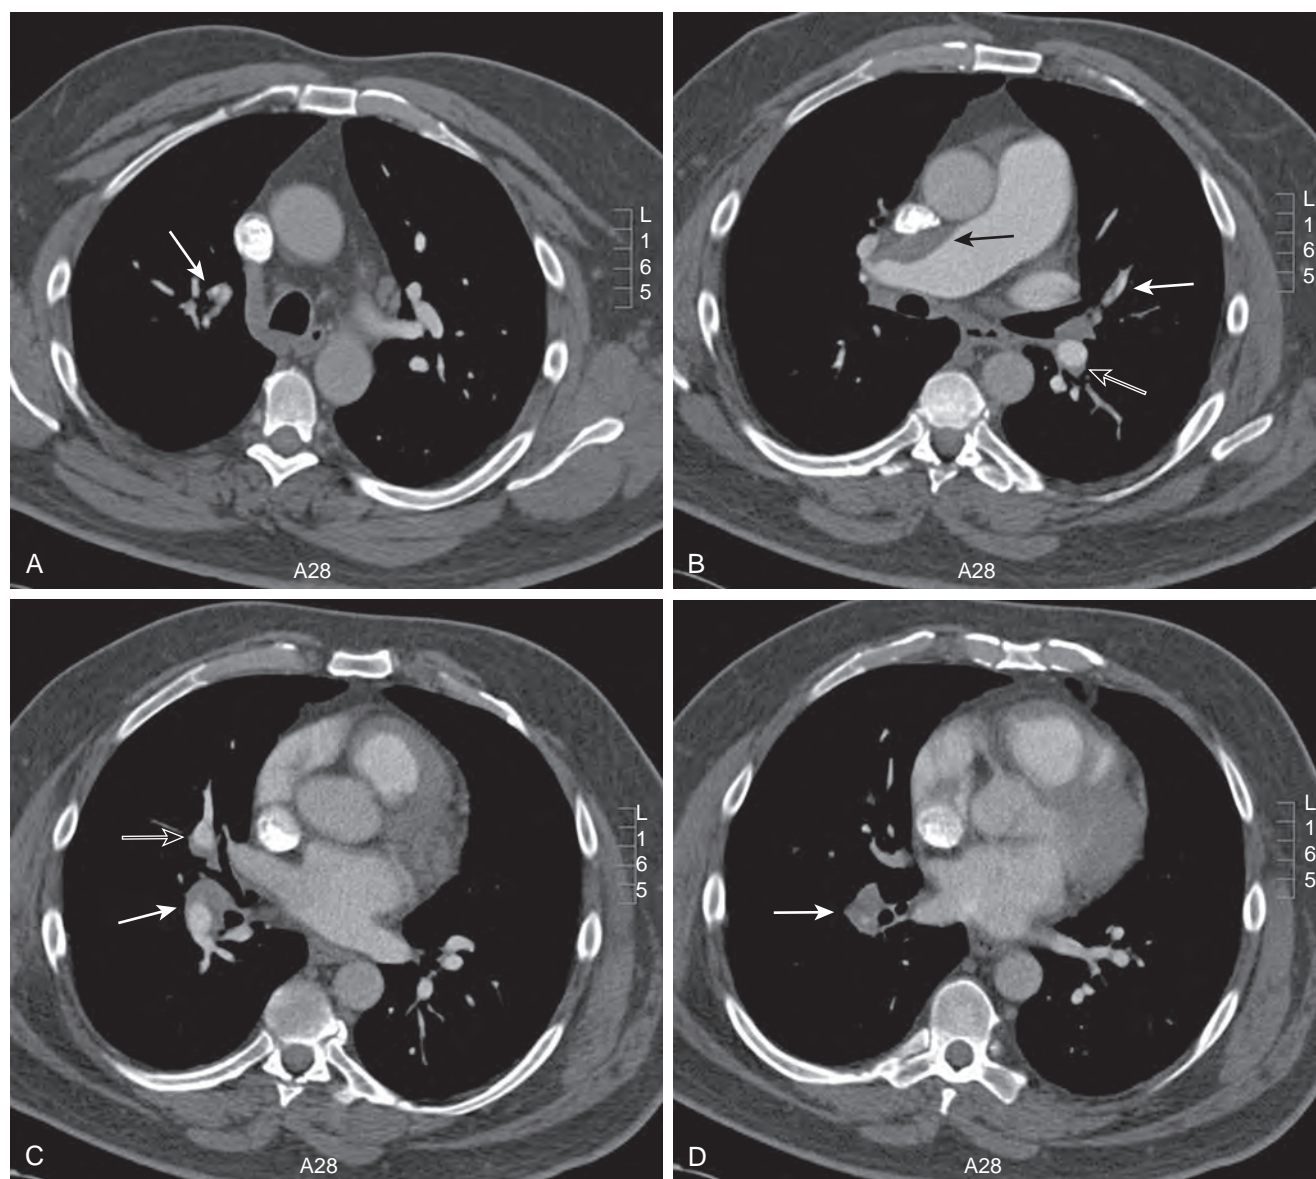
(A–D) Cephalad to caudad presentation of the computed tomography angiogram of the patient undergoing pulmonary thromboendarterectomy who was presented in previous figures showing features of chronic thromboembolic pulmonary hypertension. (A) Intravascular “web” (solid white arrow), right upper lobe segmental vessel. (B) Intravascular “web,” proximal lingula (solid white arrow), lining thrombus, right main pulmonary artery (PA) (black arrow) and intimal thickening in distal left descending PA (open white arrow). Main PA enlargement was consistent with significant pulmonary hypertension. (C) Eccentric lining thrombus, proximal right middle lobe (open white arrow) and right descending PAs (solid white arrow), leading to (D) complete occlusion and attenuation at the level of the right lower lobe vessels (solid white arrow).
